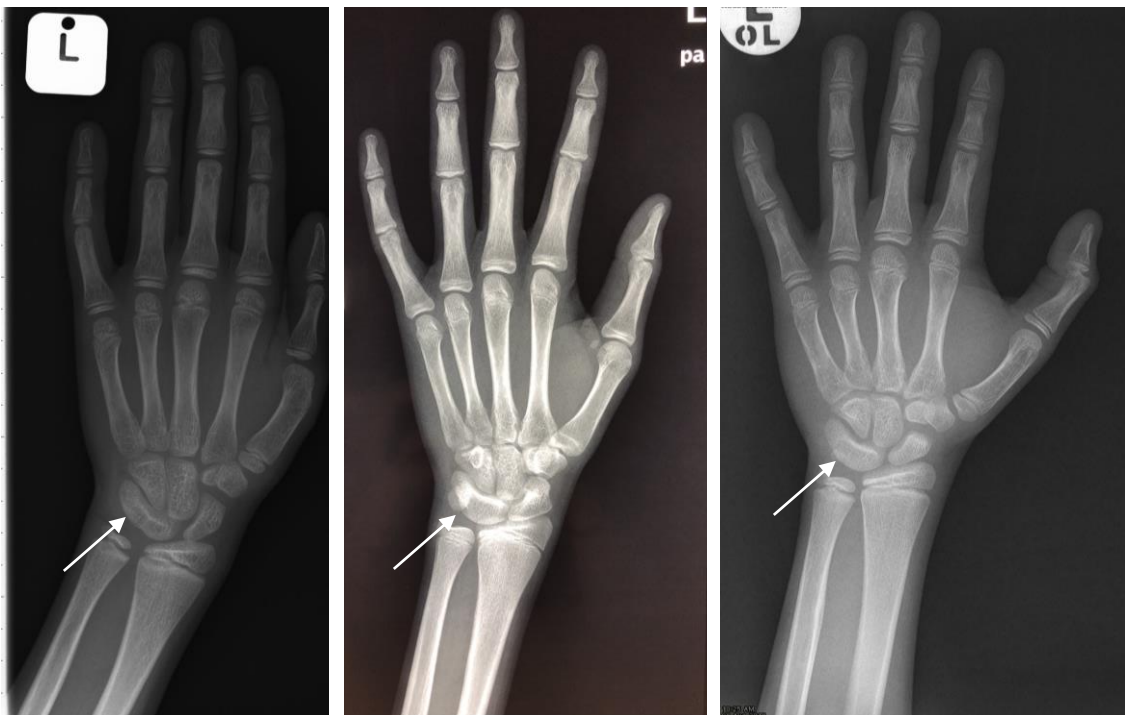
Left hand and wrist anteroposterior X-rays of three male Black South African patients with FA, demonstrating fusion of the triquetral and lunate carpal bones
